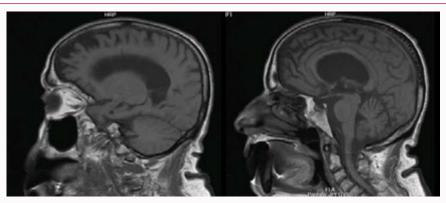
Brain MRI in T1 sequence, sagittal section. Cerebral hemispheric atrophy predominantly anterior frontal with associated ventriculomegaly.
